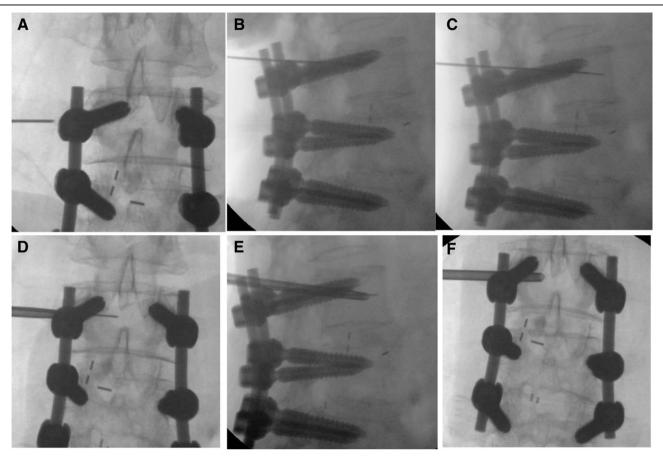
Intraoperative C-arm fluoroscopy images. A, AP X-ray showed spinal needle approaching the target (junction of pedicle and body). B, Lateral X-ray showed the spinal needle on the target. C, AP view showed spinal needle was deeper. D, Lateral view showed spinal needle was deeper. E and F, The spinal needle was exchanged for a working cannula. AP = anteroposterior.
